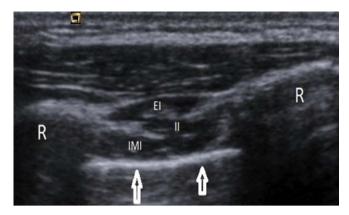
Image 1 - The normal anatomy visualized on sonography. The sagittal scan plane depicts the external (EI), internal (IE) and innermost intercostal (IMI) between rib margins (R). Arrows delineate bright echogenic interface of pleura which demonstrates no protrusion into intercostal space with exertion.
